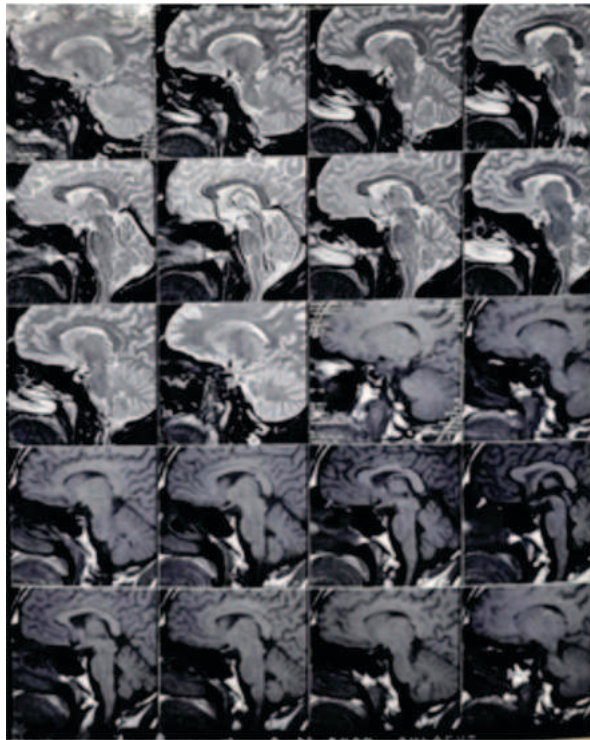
MRI Showing Hypoplastic Anterior Pituitary
